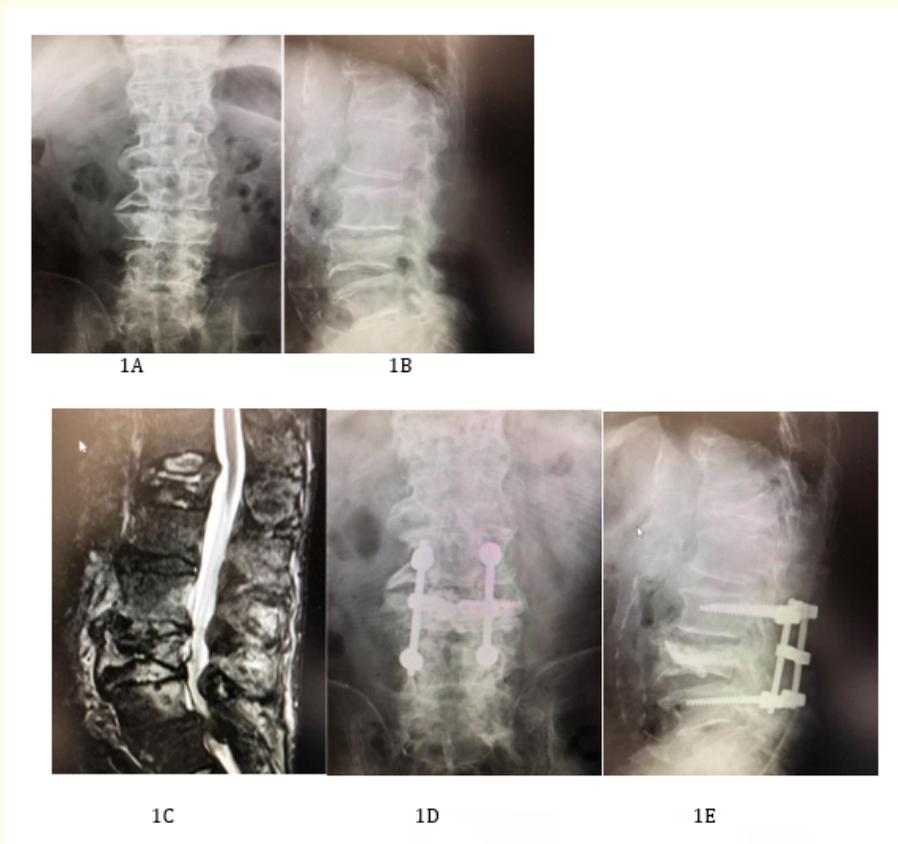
An 81-year-old man was received for laminectomy of L3 to S1, balloon kyphoplasty of L4, and instrumented fusion from L3 to L5. 1A: Preoperative XP AP view. 1B: Preoperative XP lateral view. 1C: MRI view. 1D: Postoperative XP AP view. 1E: Postoperative XP lateral view.
